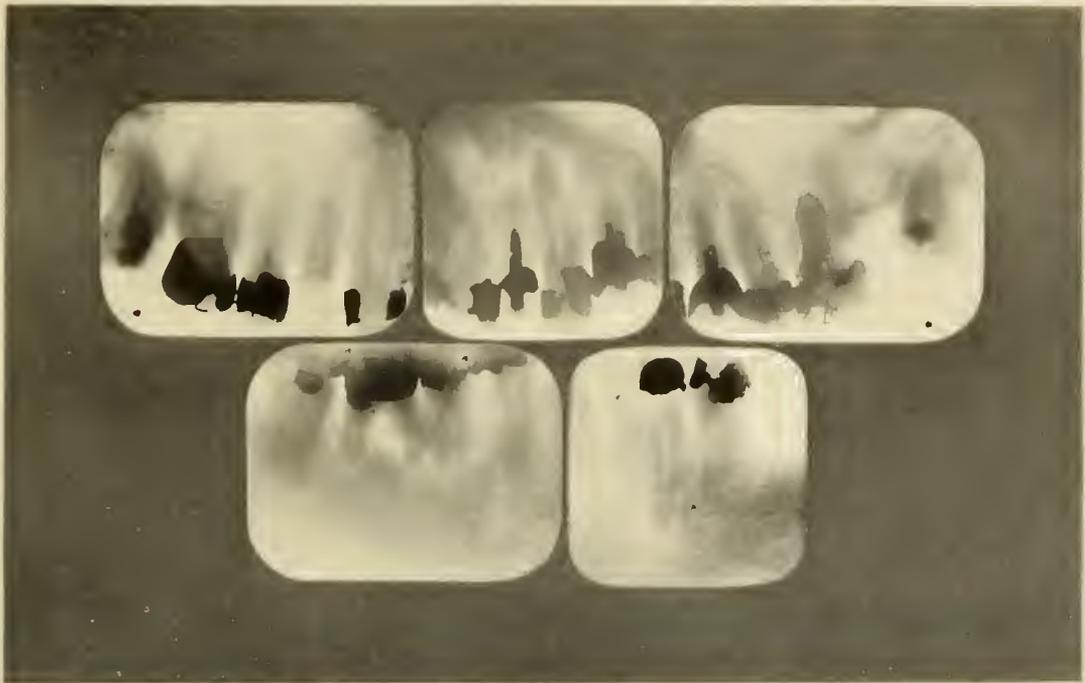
ROENTGENOGRAPHIC APPEARANCE OF THE TEETH OF CASE NO. 484; PATIENT SUFFERING WITH RHEUMATIC NEURITIS AND HEART, WITH EXTREME MUSCLE ATROPHY.
